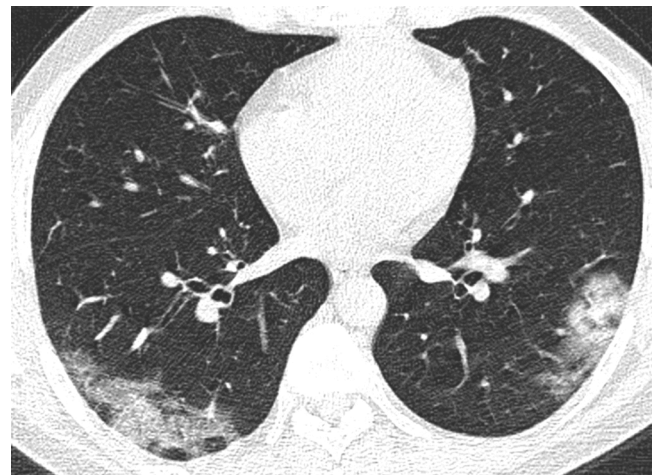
Mild extent of opacifications. Axial reconstruction of a CT in lung window showing mild affection with ground glass opacities and minor consolidation in the periphery of both lower lobes.
